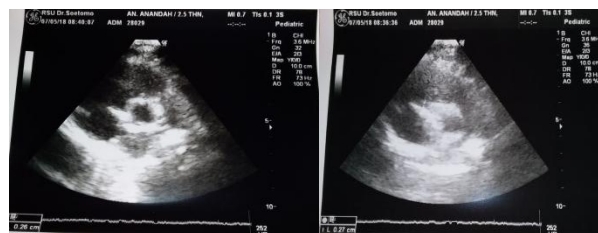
Echocardiography assessment: LCA (2.6mm), RCA (2.7mm)
